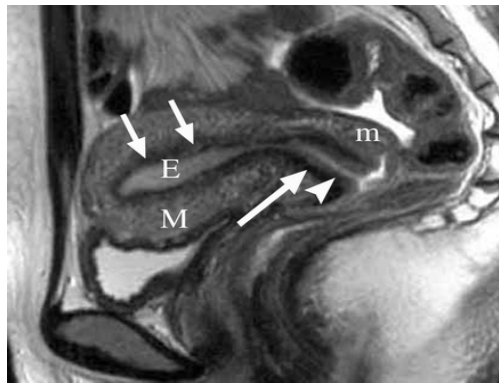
Normal uterus in a woman of reproductive age. Sagittal T2-weighted image of the uterus shows the endometrium (E), junctional zone (short arrows), and myometrium (M). It also shows the epithelium (arrowhead), fibrous stroma (long arrow), and peripheral myometrium (m) of the cervix (*Quoted from Izumi et al., 2003*).
